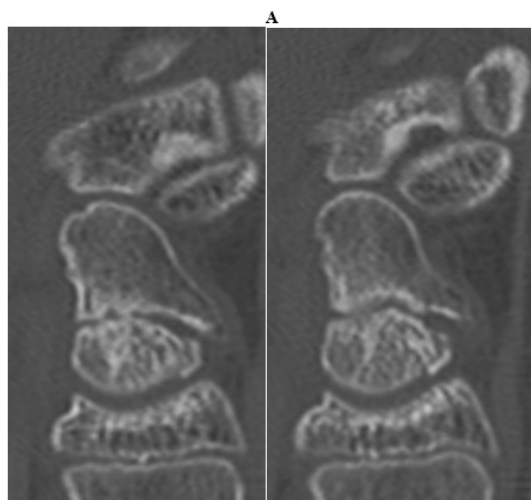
A) CT scan after 3.5 months of immobilisation - detection of early bone bridging. B) CT scan after 6 months of immobilisation - callus formation.
